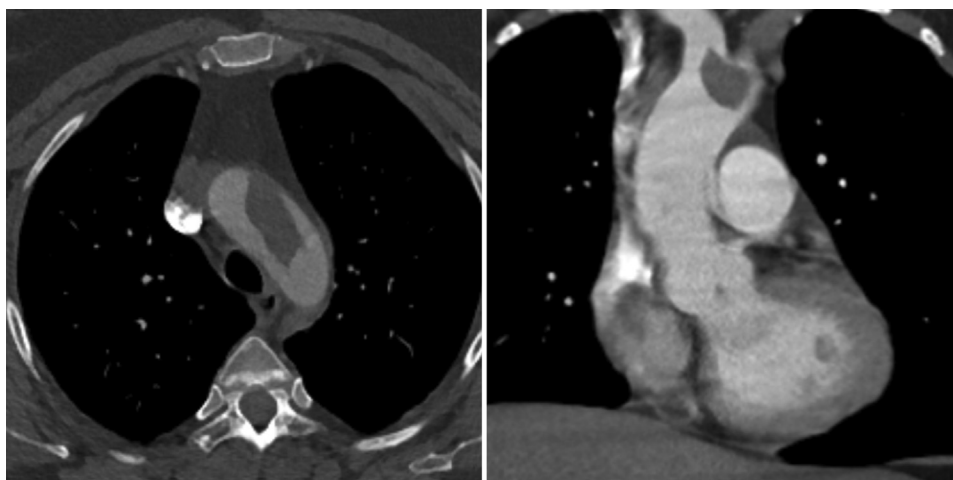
CT images of floating aortic arch thrombus (patient number 7).
